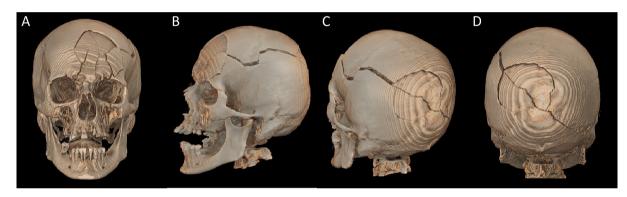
3D reconstruction of the head CT scan of the patient (A: frontal view, B: left anterior oblique view, C: left posterior oblique view; D: posterior view).
